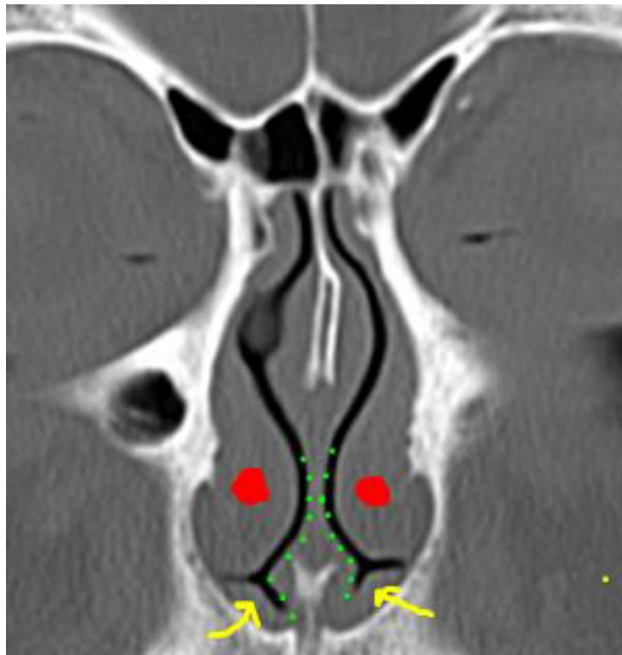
NVB swell bodies as seen on sinus CT imaging, coronal view. NVB hypertrophy contributes to crowding and obstruction of the lower aspect of nasal airway. *Yellow arrows* bilateral NVBs, *red circle* hypertrophied inferior turbinate; *green-dotted lines* borders of nasal septum, with small anterior spurs present at the maxillary spine. Note: CT shown derives from a different patient than shown in Fig. 1
